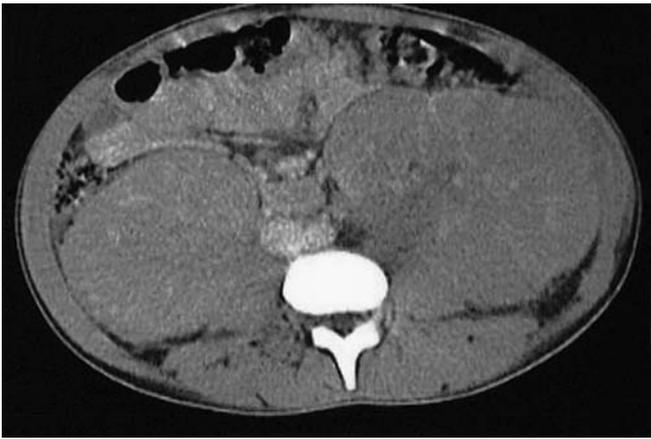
Contrast-enhanced computed tomography of the abdomen. Bilateral enlarged kidneys with multiple hypodense areas and para-aortic multiple enlarged lymph nodes were noted
